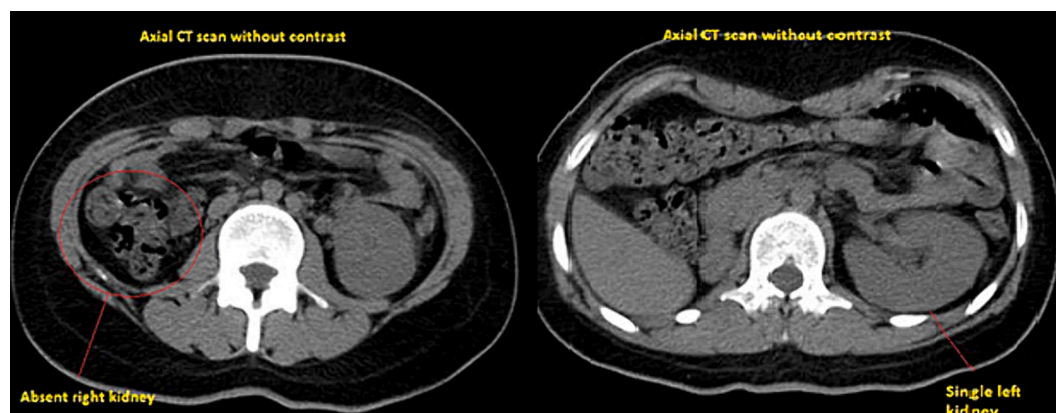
CT scans showing single normal-looking left kidney and congenital absent right kidney.
